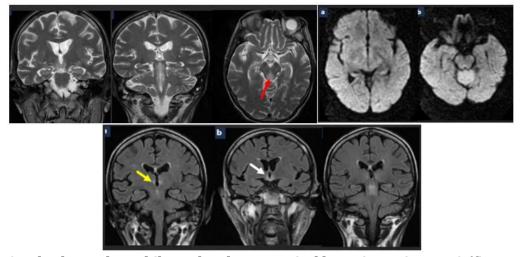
Cerebral MRI shows bilateral and symmetrical hyperintensity on T2 (figure 1), FLAIR (figure 2) and on diffusion weight images (figure 3), marked around V3 walls (yellow arrow), around the aqueduct of Sylvius (red arrow) and at the level of the mammillary tubercles (white arrow) suggestive of Gayet Wernicke syndrome.
